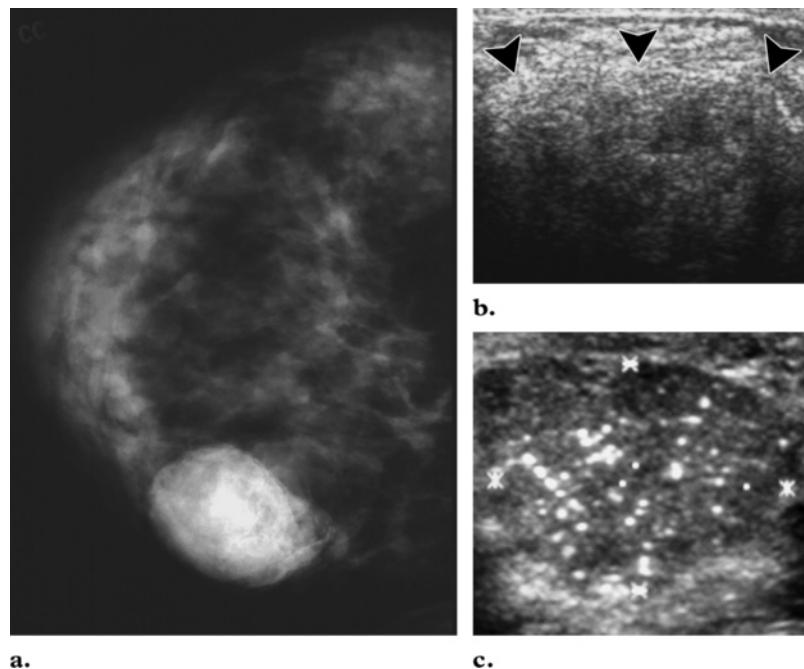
Lactating adenoma. (a) Mediolateral oblique mammogram of a 17-year-old girl shows a posterior, dense, well-circumscribed mass. (b) Corresponding sonogram shows a heterogeneously echogenic mass (arrowheads) with posterior shadowing. (c) Sonogram of another patient shows small hyperechoic foci within a mass, findings that represent the fat in the milk produced by the tumor.
